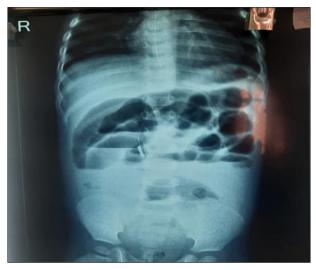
X-ray Abdomen erect [multiple air fluid level suggestive of intestinal obstruction]
